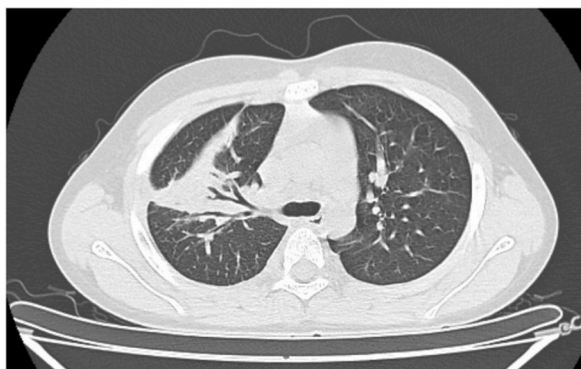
Follow-up chest CT scan on day 44 of admission showing magnificent improvement of the right consolidation.
